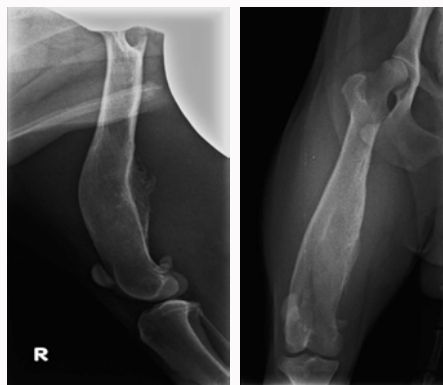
Orthogonal radiographic projections (medio-lateral and craniocaudal views) of the bone lesion after nine months. The lytic lesion is no longer evident while the “palisading” proliferative reaction is significantly reduced. Focal deviation and thickening of the distal third of the femoral diaphysis persist.
